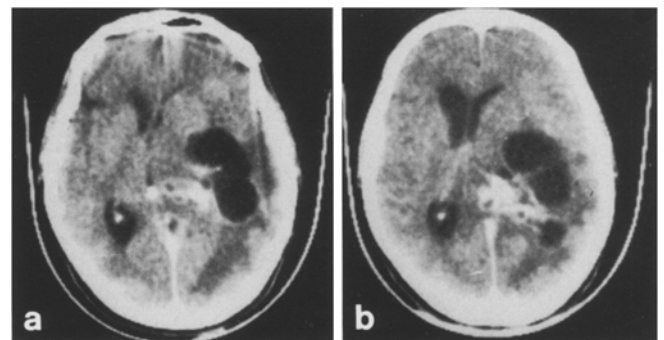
Enhanced CT scans showing multilocular hydatid cysts in the left temporo-occipital region. The cysts are polygonal in shape and like a bunch of grapes. Enhancement and perifocal oedema are seen
